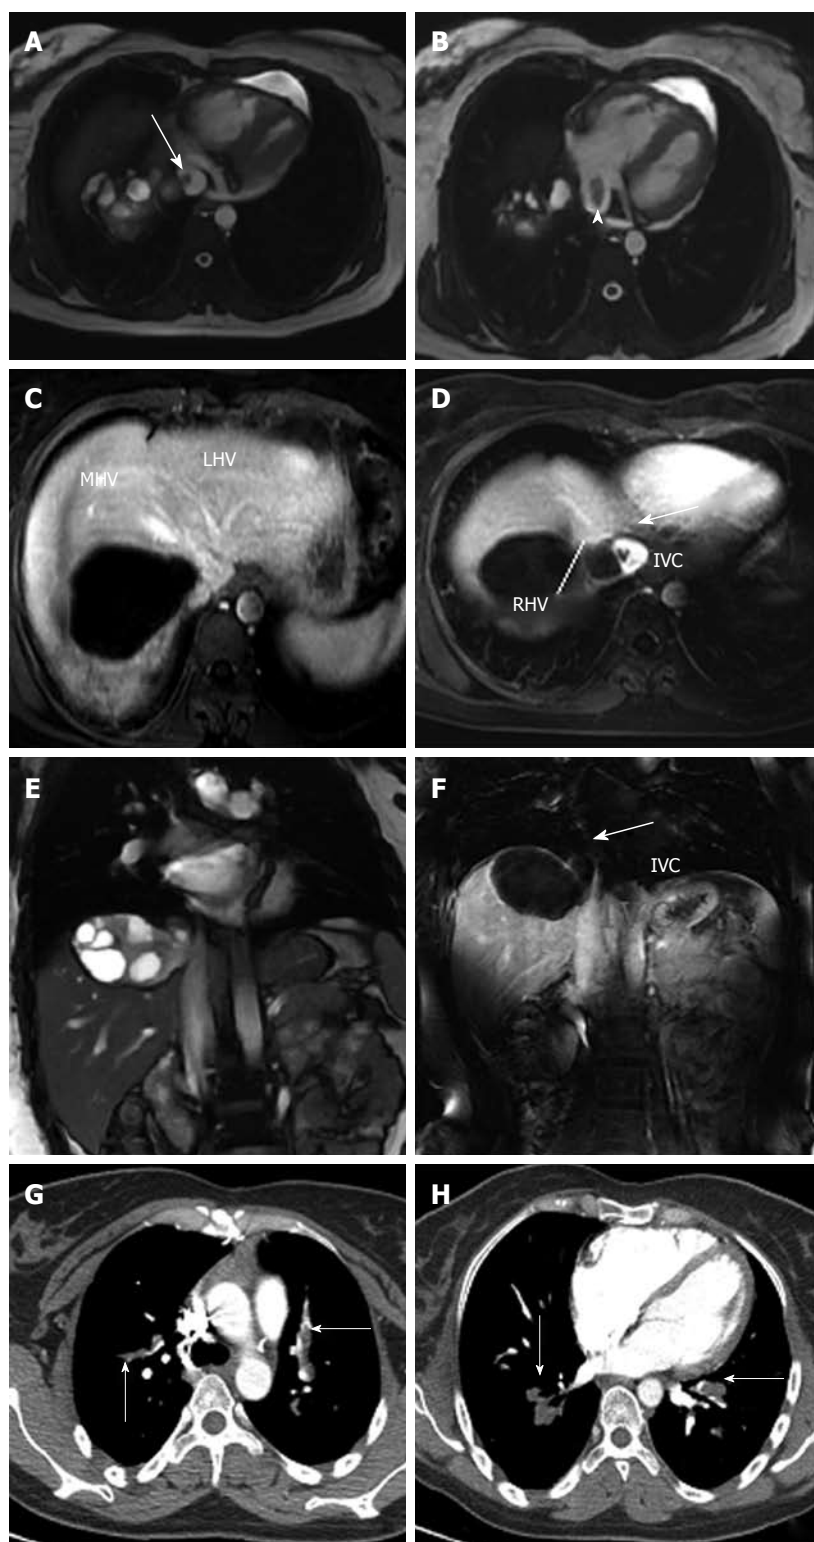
Hepatic hydatidosis in a 30-year-old woman who presented with short of breath, fatigue and edema to the lower limbs. Magnetic resonance (MR) steady-state-free-precession sequences (A, B, E) and MR angiography (C, D, F) images showed the hydatid cyst invading the right hepatic vein (RHV), protruding in the inferior vein cava (IVC) (the bold white arrow) and in the right atrium (the white arrowhead). The mid hepatic vein (MHV) and the left hepatic vein (LHV) were normally patent (C). The multidetector computed tomography-angiography revealed diffuse pulmonary parasitic embolism (the thin white arrows) (G, H).
